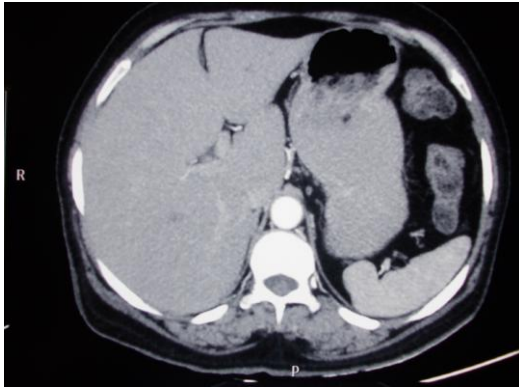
Pre operative CT Scan of patient.
